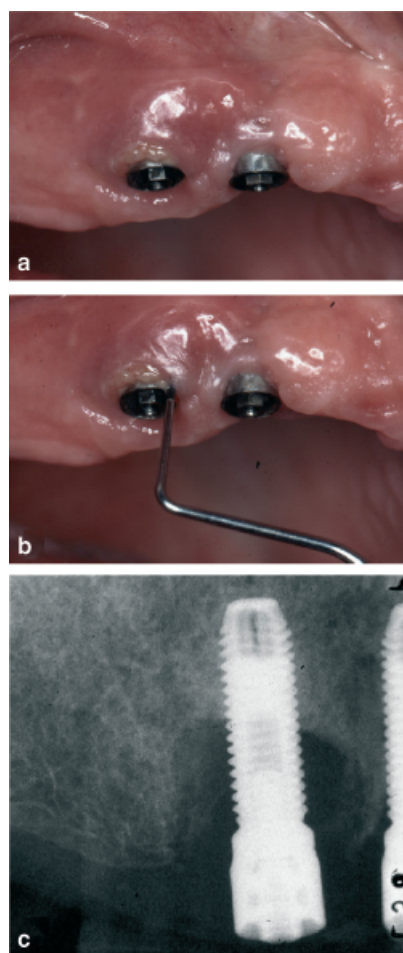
Clinical symptoms of periimplantitis site R3 of subject BA. Note the swelling (a), the suppuration during probing (b) and the crater-shaped bone defect in the radiograph (c).
